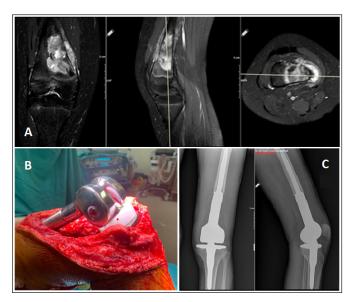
A) Images of osteosarcoma localized in the distal femur in different sections in MR T2 sequence B) Endoprosthetic prosthesis application after resection C) Postoperative AP and lateral radiographs
